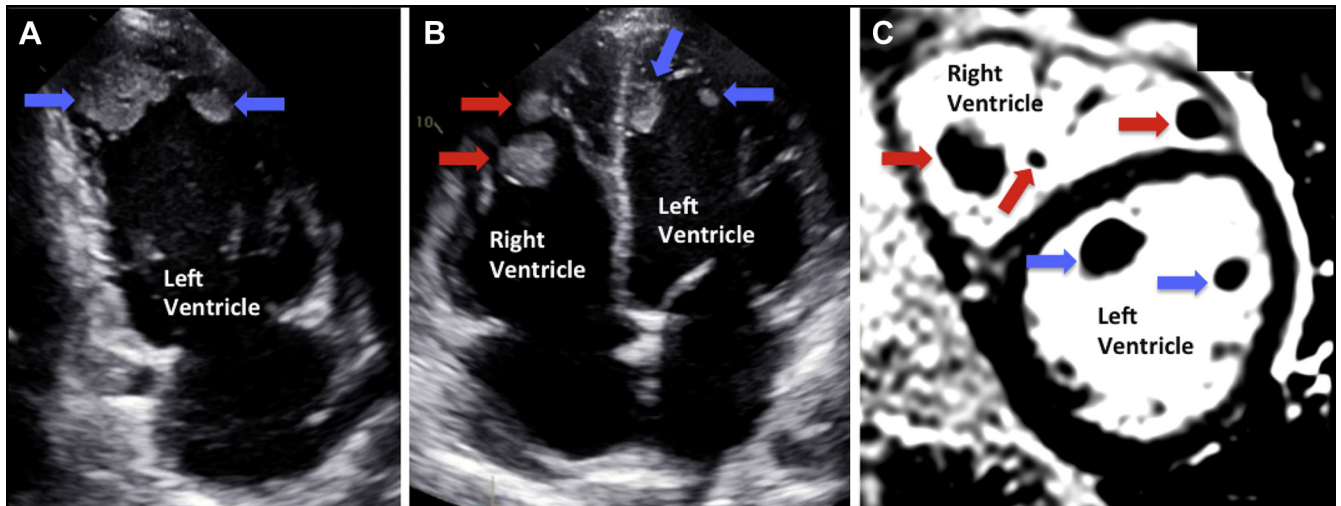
Figure Panels A and B: Transthoracic echocardiogram images. (A) Apical 2-chamber view shows multiple large thrombi in the left ventricle. (B) Apical 4-chamber view shows multiple large thrombi in the left and right ventricle. (C) Cardiac magnetic resonance imaging contrast-enhanced image confirms the nonenhancing masses as multiple thrombi in both ventricles.
